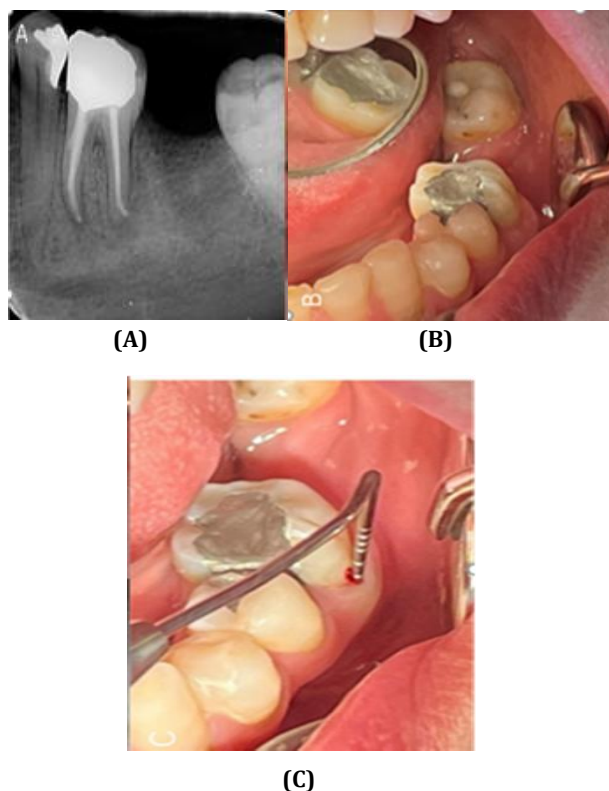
A) Initial PA demonstrating resolved periapical lesion, B) Clinical view showing intact buccal mucosa and healthy gingival margins, C) Periodontal probing (3 mm) and BOP
